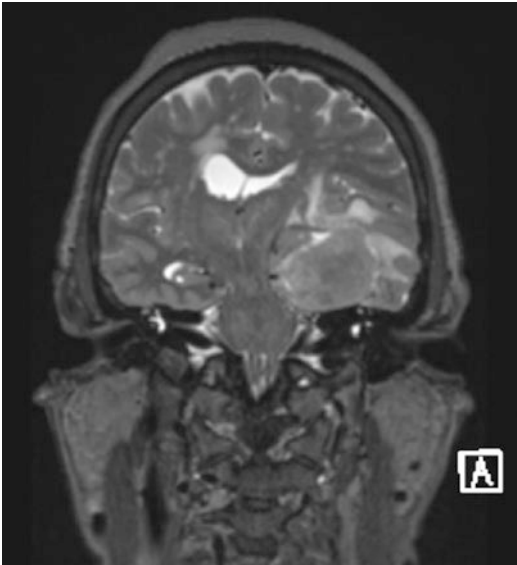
Midcoronal section MRI view showing a middle cranial fossa meningioma with mass effect, subfalcine herniation, distortion of midbrain
